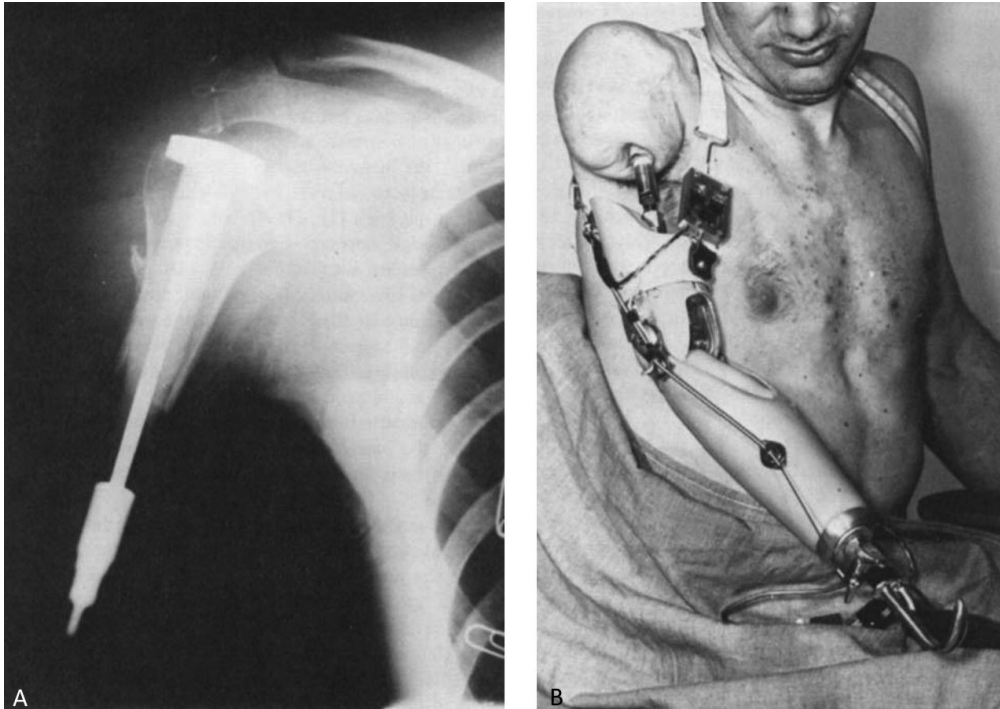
Cerosium implant used by Dr. Vert Mooney in 1967. A) Radiograph and B) clinical photo of patient with a right humerus implant. Figures adapted with permission from Mooney V, Predecki PK, Renning J, Gray J. Skeletal extension of limb prosthetic attachments—Problems in tissue reaction. *Journal of Biomedical Materials Research*. 1971 Nov;5(6):143-59.
